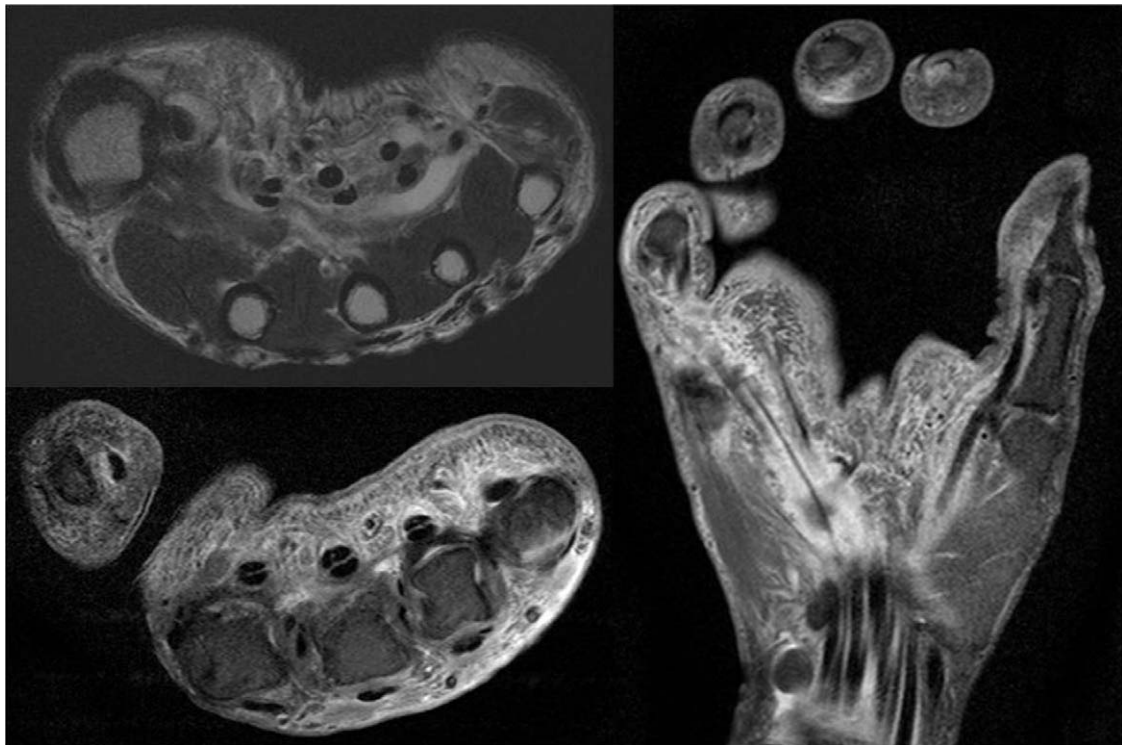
A contrast-enhanced magnetic resonance image demonstrating fluid collection with distension, and the common flexor tendon sheath, radial and ulnar bursae, and first and fifth flexor tendon sheaths showed diffuse inflammation around the tendon sheaths and adjacent lumbrical muscles.
